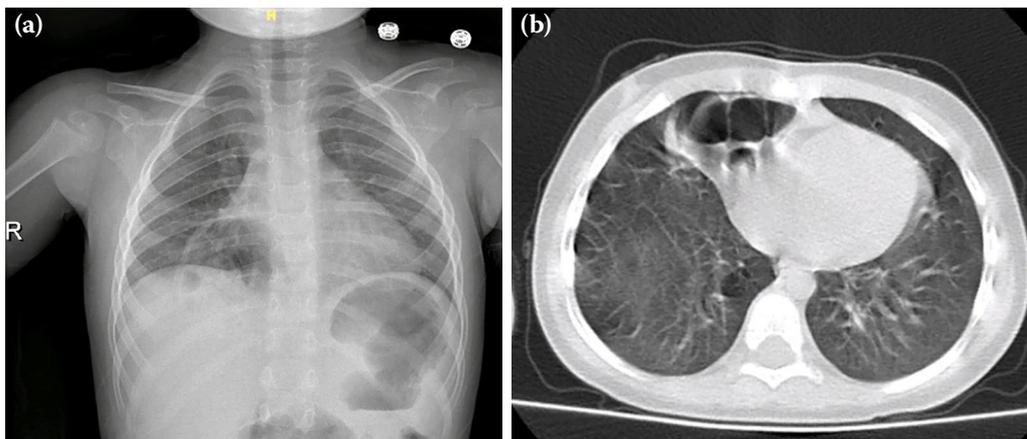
Chest X-ray (a) and computed chest tomography (b) of a representative case with Morgagni hernia. The chest X-ray demonstrates a retrosternal radiolucent area in the right hemithorax consistent with bowel herniation. The CT scan confirms the presence of abdominal viscera herniating through the anterior diaphragmatic defect into the thoracic cavity. CT, computed tomography.
